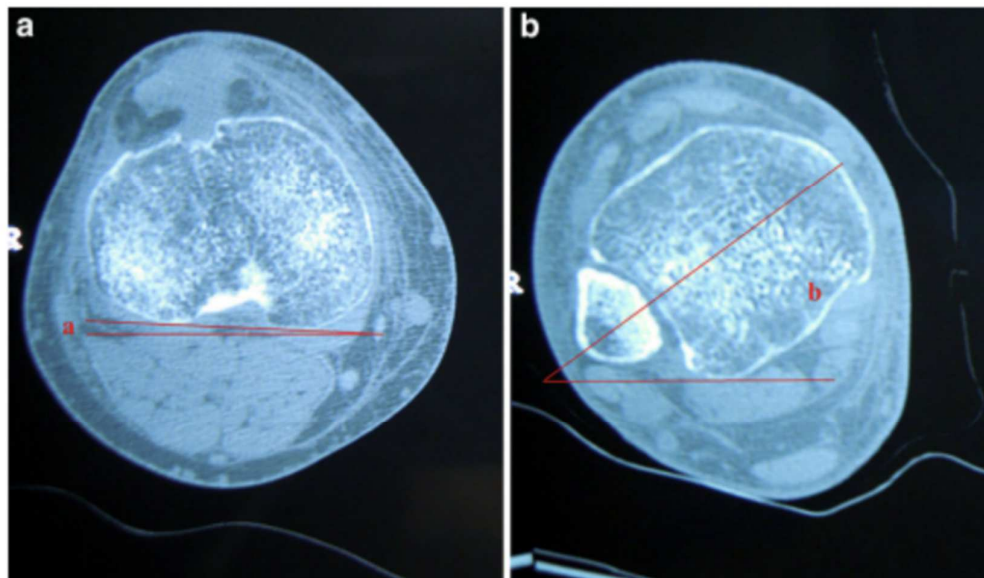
Tibial rotation is measured using CT slices in two ways: (a) the angle ‘a’ between the tibia's posterior cortex and the transverse axes on the proximal slice, and (b) the angle b’ between the transverse axis on the distal slice and the line that passes through the center of the fibula and tibia. The leg's rotation was measured (a+b), and the rotational difference was calculated by comparing it to the healthy side.
